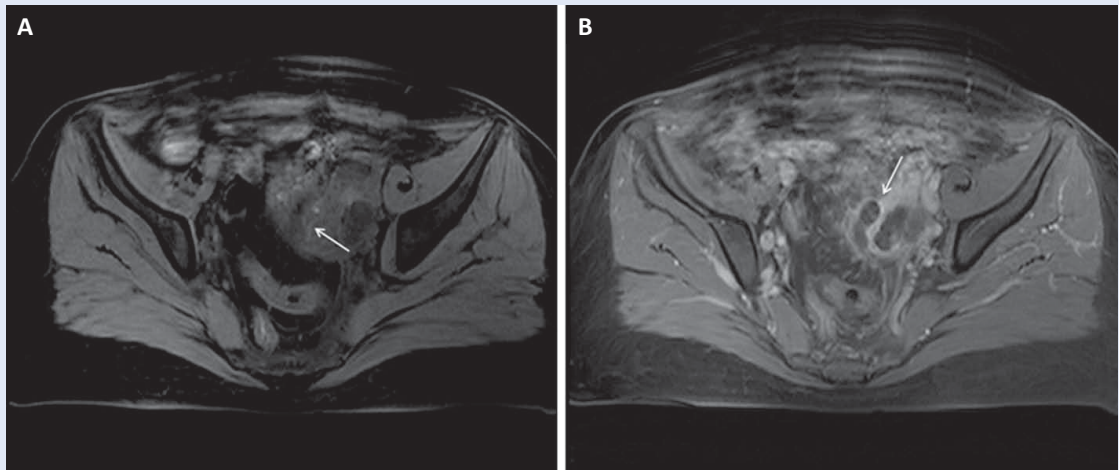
MRI images of a tubo-ovarian abscess (A – axial plane, T1 weighted image, “penumbra sign”; B – axial plane, T1-weighted contrast-enhanced image, multilocular, cystic, pelvic mass with solid component).
